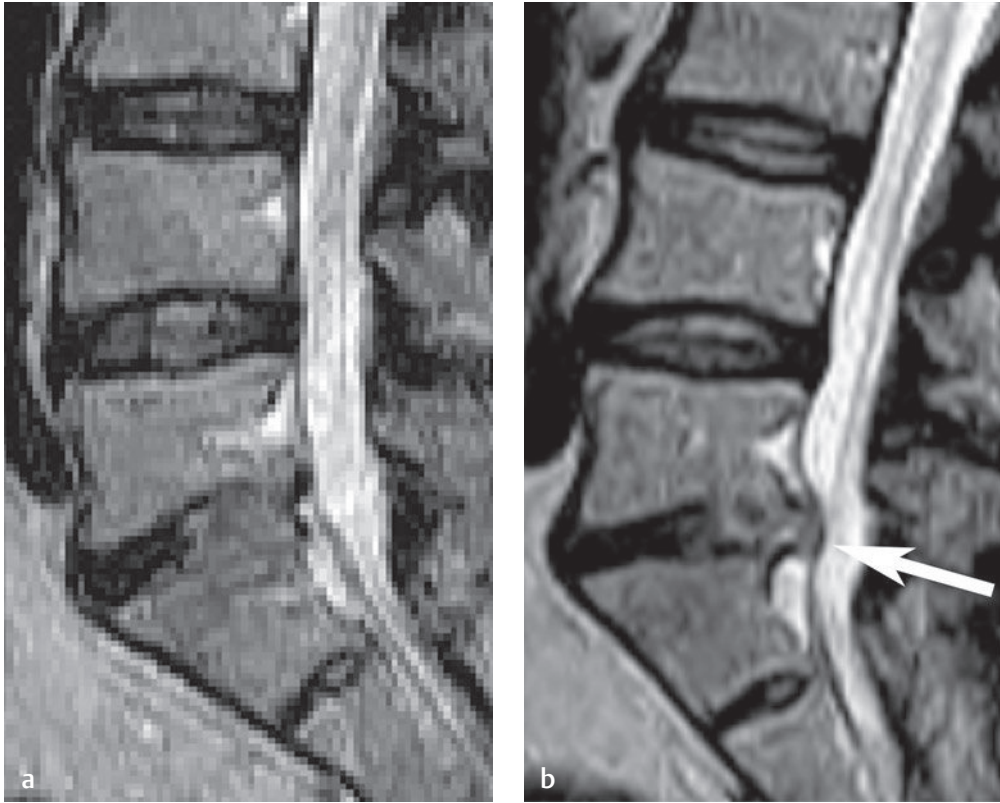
Load-bearing spine imaging: standing positional paradigm. These sagittal T2-weighted views were obtained in a specially designed open 0.6-T magnet that allows both horizontal (recumbent) and vertical (upright) imaging (Fonar Corp.). This patient had recurrent radiculopathy 8 months after partial discectomy, with symptoms only when upright. (a) A supine image shows no focal contour abnormality at L5-S1. (b) An upright-neutral image reveals a posterior disc herniation at the L5-S1 level, elevating the posterior longitudinal ligament (*arrow*), which was not visible on the supine image.[†] (Courtesy of J. Randy Jenkins, MD, FACR, FEC, Downstate Medical Center, State University of New York, Brooklyn, NY.)
